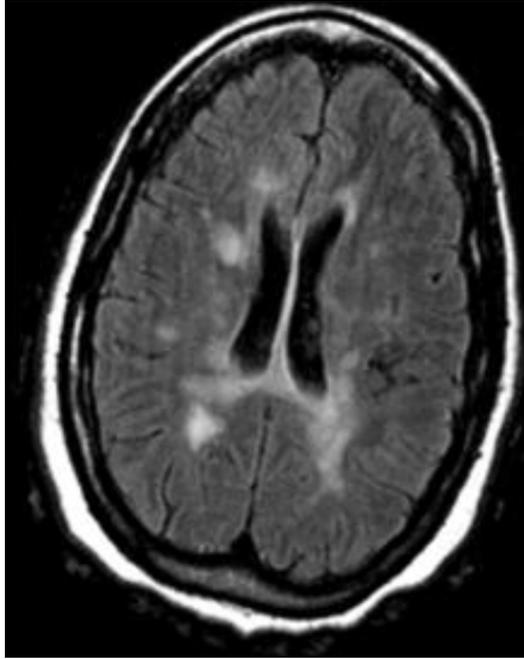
Axial FLAIR image demonstrates typical periventricular lesions so called, Dawson fingers.
